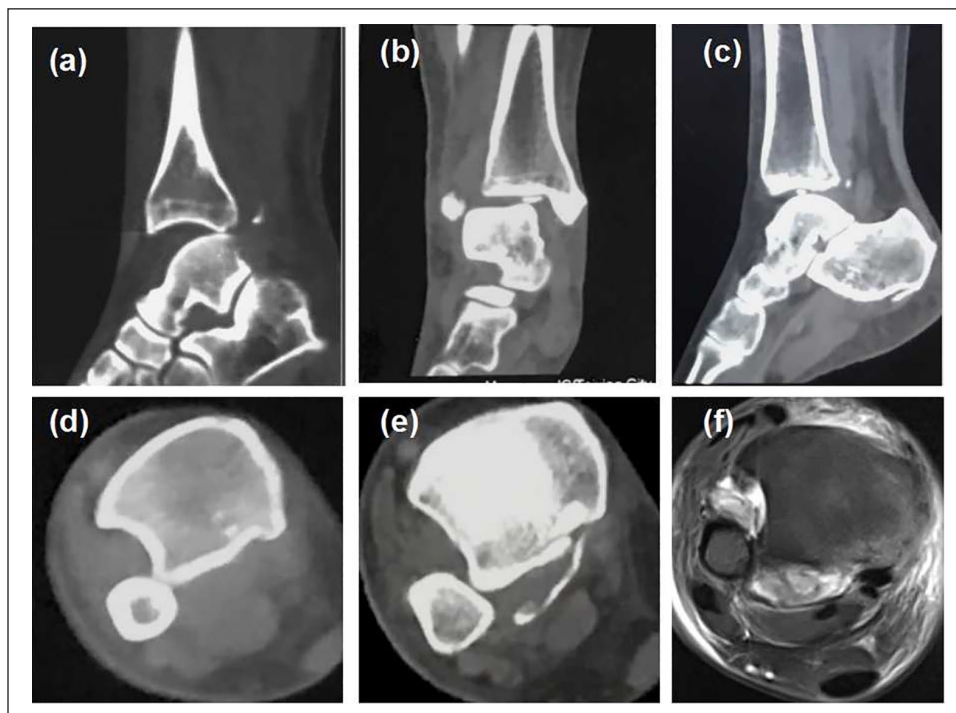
Preoperative CT and MRI images after manually closed reduction. (a) Posterior subluxation of talus and avulsed fractures of the posterior malleolus on the lateral view of CT scan. (b, c) Loose osteochondral fragments in the tibiotalar joint space on both the coronal and the sagittal views of CT scan. (d–f) Distal fibula posteriorly displaced from the normal tibial notch and fixed behind the posterolateral tibial tubercle, and avulsed fracture of the posterior malleolus on an axial view of CT and MRI images.
